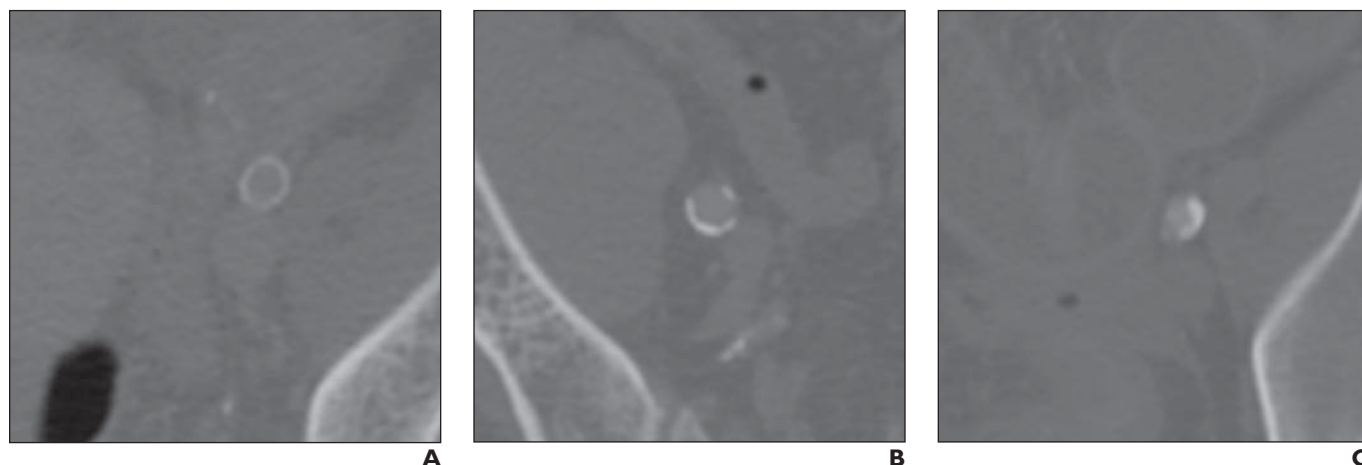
CT scans show findings that are characteristic of different calcification morphology scores.
